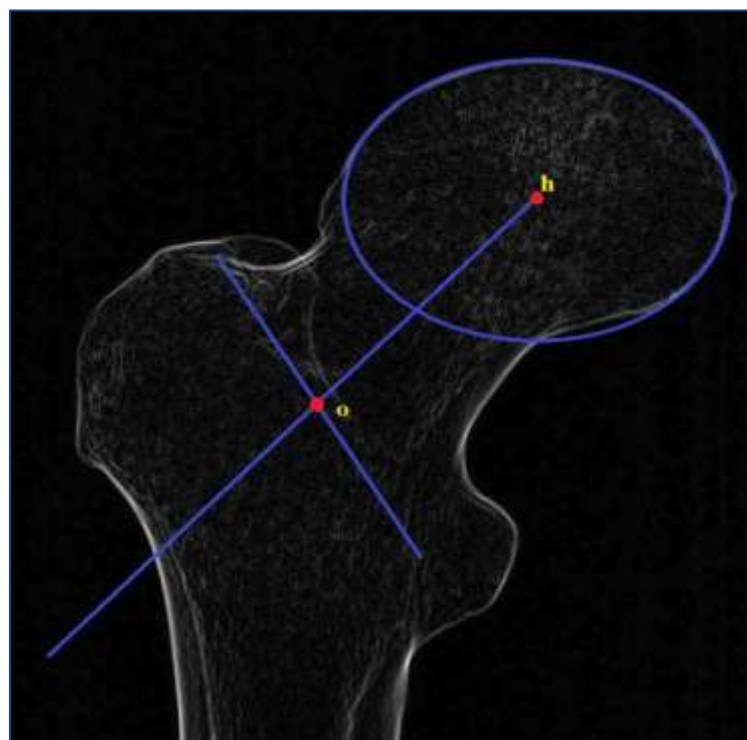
Landmark selections estimating centre femoral head (h) and femoral neck centre (o) in AP radiographs.
